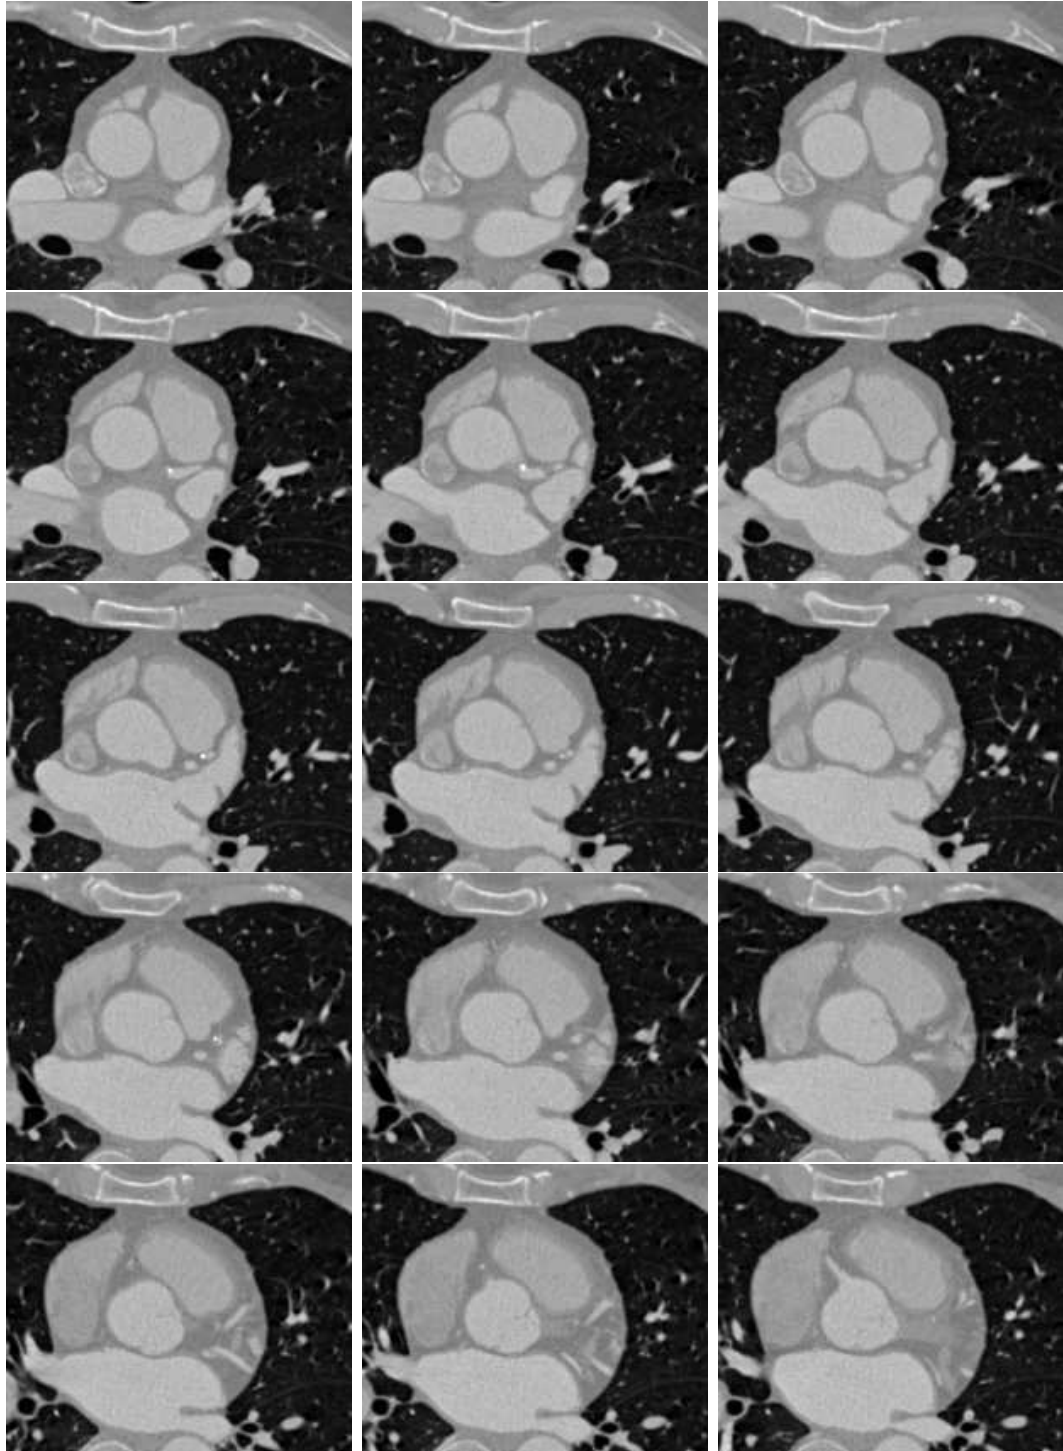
Original coronary artery CTA images, Dataset #1, Part I.
